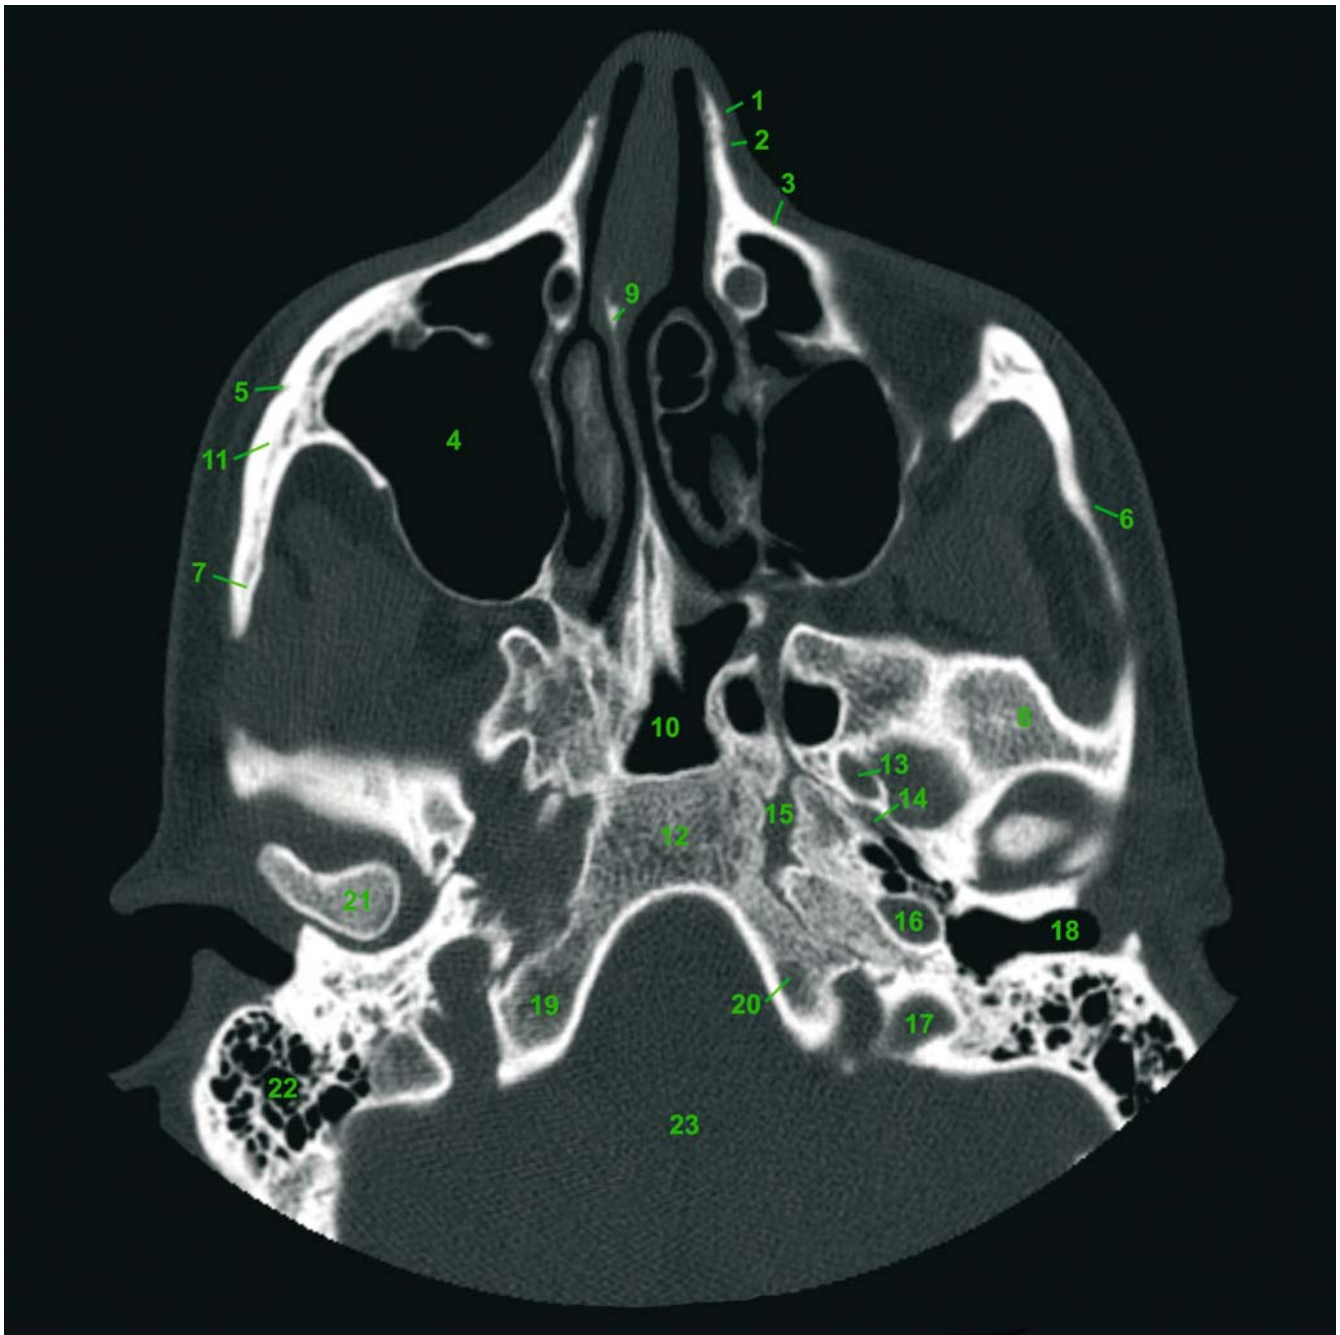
Axial CT slice 5 (patient K.C.). 1 Nasal bone; 2 Nasomaxillary suture; 3 Maxillary bone; 4 Maxillary sinus; 5 Zygomaticomaxillary suture; 6 Zygomaticotemporal suture; 7 Zygomatic arch; 8 Temporal bone; 9 Nasal septum; 10 Sphenoidal sinus; 11 Zygomatic bone; 12 Clivus; 13 Oval foramen of sphenoid bone (foramen ovale); 14 Spinous foramen (foramen spinosum); 15 Foramen lacerum; 16 Carotid canal; 17 Jugular foramen (foramen jugulare); 18 External acoustic meatus; 19 Occipital bone; 20 Hypoglossal nerve canal; 21 Condyle of mandible; 22 Mastoid air cells; 23 Posterior cranial fossa
